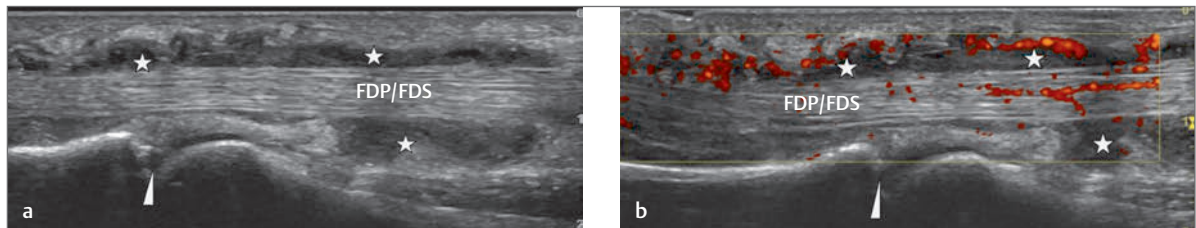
(a) Longitudinal image of the volar aspect of the metacarpophalangeal joint (*white arrowhead*) of a left middle finger demonstrating intact tendons of flexor digitorum profundus and flexor digitorum superficialis (FDP/FDS). However, a marked effusion and synovitis can be seen within the flexor sheath (*white stars*). The underlying metacarpophalangeal joint appears intact. (b) The use of Power Doppler imaging demonstrates that this effusion and synovial thickening is associated with an active synovitis (*white stars*). These findings are in keeping with a chronic flexor sheath tenosynovitis. White stars, effused joint with synovial thickening and an active synovitis as demonstrated with Power Doppler imaging.
